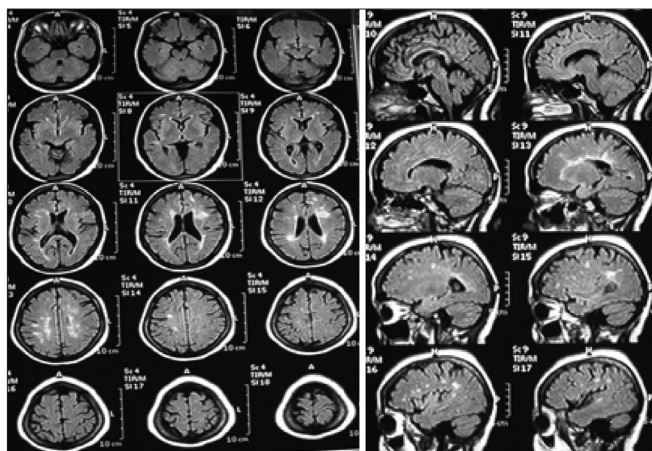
Brain magnetic resonance imagine; axial view (a) and sagittal veiv (b) of multiple sclerosis patient two months after treatment
